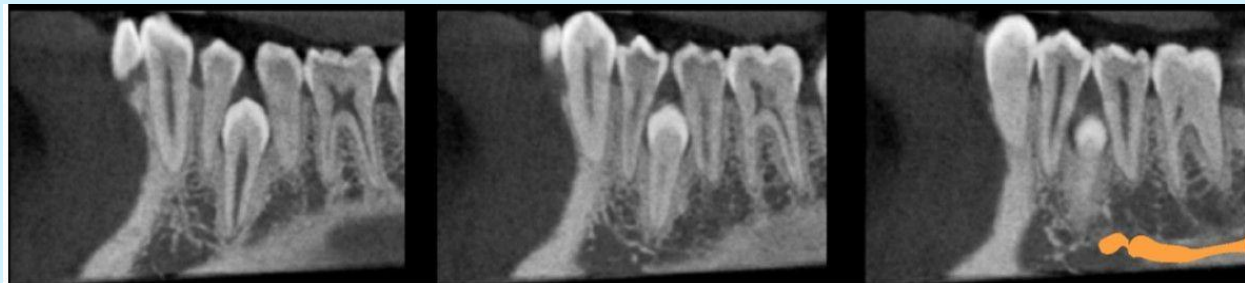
CBCT image, oblique sagittal slices
